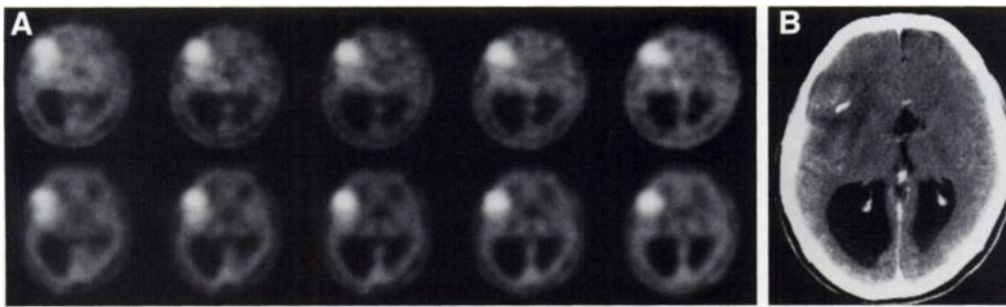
(A) Comparison of IMT-SPECT scans (upper row) and MET-PET scans (lower row) (15–60 min postinjection) in an astrocytoma Grade II (Patient 5). The extent of the tumor area with increased tracer uptake appears to be identical for IMT and MET. (B) The contrast-enhanced CT scan of Patient 5 shows no major contrast enhancement in the tumor area indicating that there is no blood-brain-barrier disruption.
